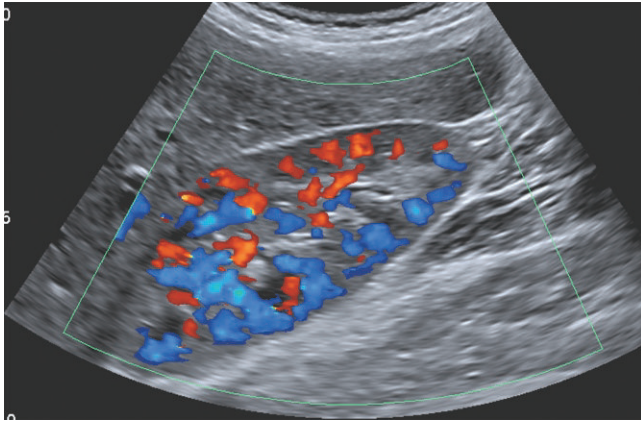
Color Doppler of the kidney shows red and blue signals. There is a paucity of color at the cortex and the upper and lower poles due to low flow and poor Doppler angle.
